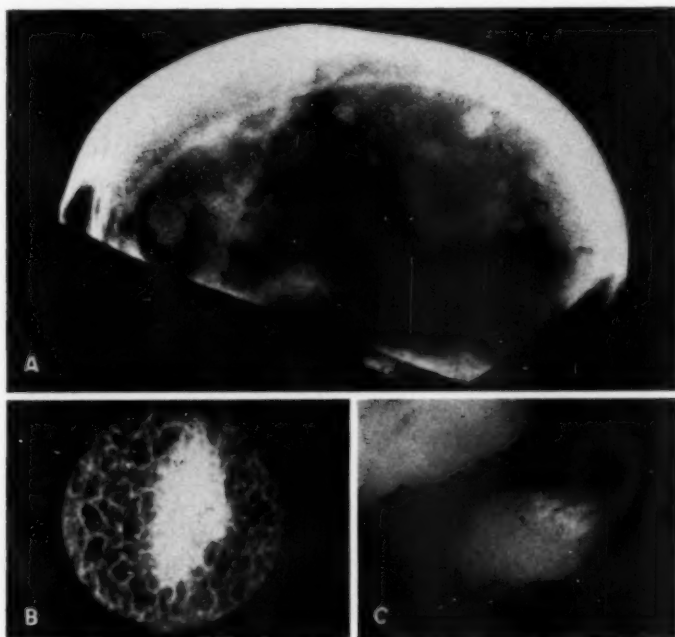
A. Postmortem roentgenogram of calvarium of patient shown in Figure 2. The fact that the brain has been removed proves unequivocally that the islands of increased density are within the calvarium. B. Detail view of one of the sclerotic plaques. *Pathologist's Report*: "The dense patches in this bone were areas of osteosclerosis, in which the marrow spaces of the cancellous bone had largely disappeared, owing to a concentric development of bone on the previous trabeculae. There was no evidence of neoplasm. It was evident that in the region of osteosclerosis the marrow was fatty instead of cellular. I am not prepared to make any suggestion as to why one region rather than another, was selected for the change."—C. V. Weller, M.D.
